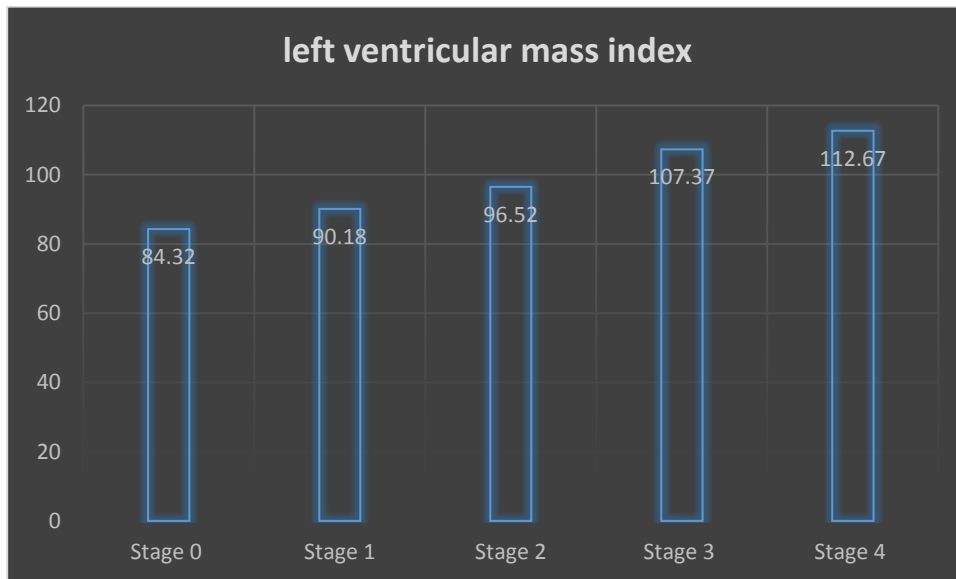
Comparison of left ventricular mass index in Echocardiographic Findings between Hypertensive Retinopathy (HR) Stages
